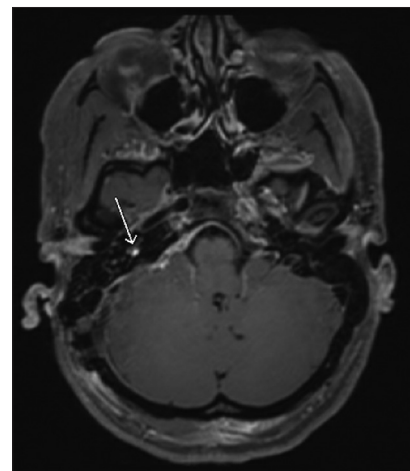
T1-weighted magnetic resonance imaging with contrast following right retro sigmoid craniectomy for tumor resection. Of note a small nodular area of enhancement is seen near the right vestibule (arrow).
